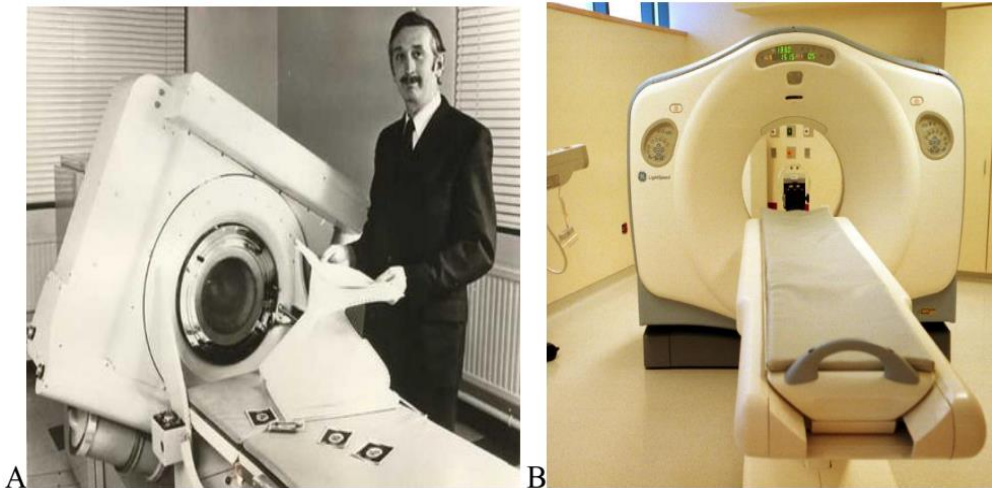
Old (A) and Latest (B) CT scanner systems.
